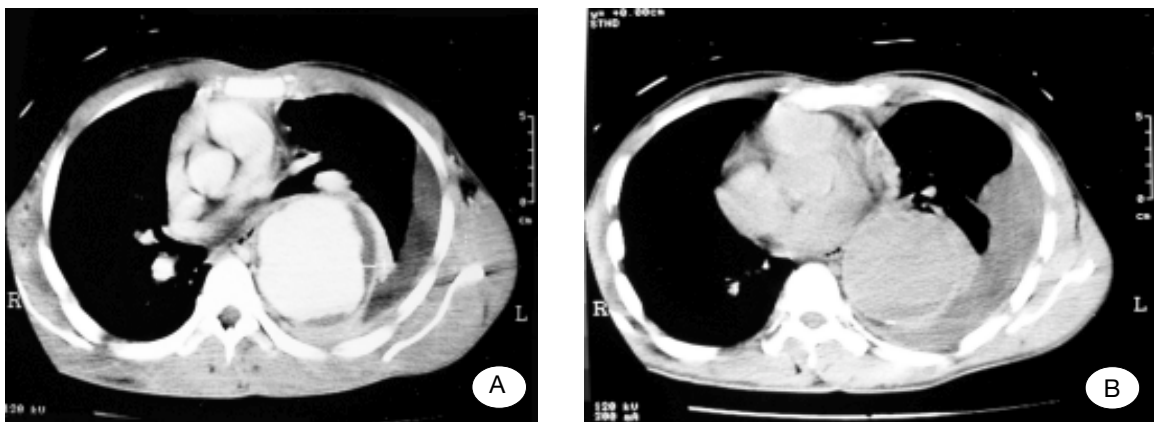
CT scan without (A) and with contrast enhancement(B), 2 months before surgery shows a 7.8 cm in diameter, fusiform aneurysm at level distal aortic arch and descending aorta with mural thrombus, more on the posterolateral wall. Rim calcification with intimal irregularity are seen. Left pleural effusion is also detected.
